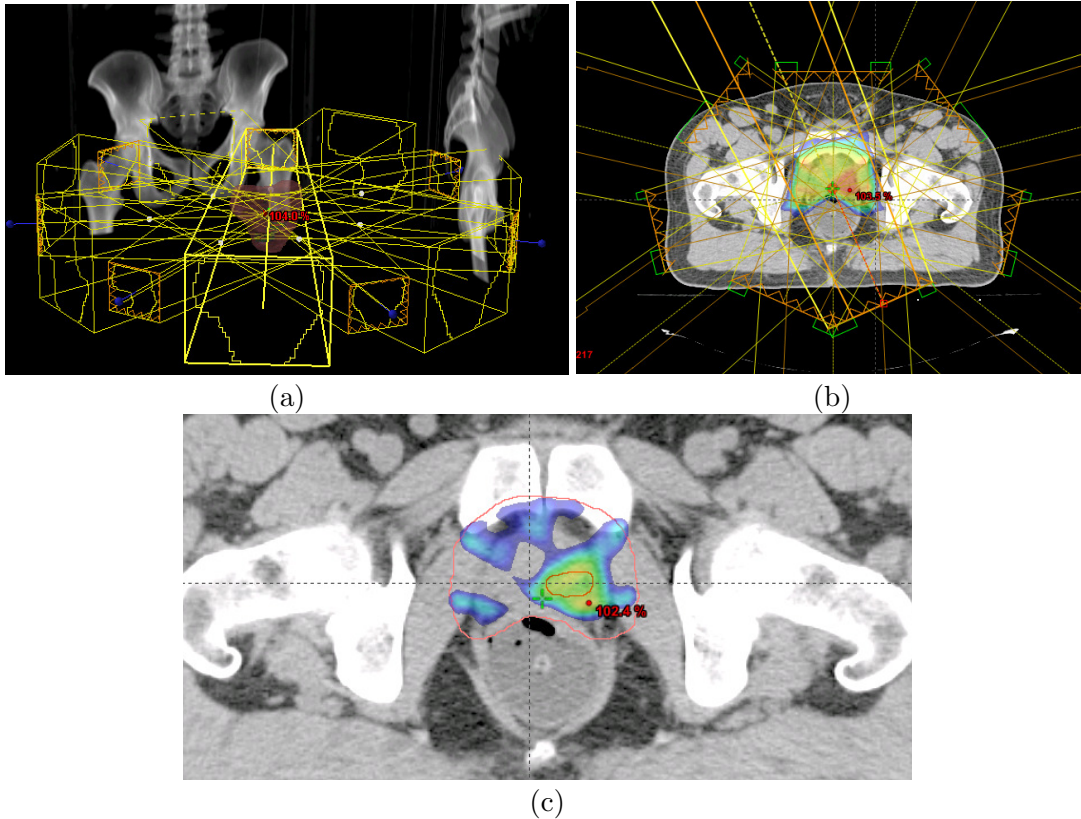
(a) 3D visualization of the orientations and shapes of the 7 dynamically shaped radiation beams used to design the IMRT dose plan. (b) Axial view of a CT slice with the 7 beams and the resulting dose map thresholded at 7920 cGy (minimum dose for the PTV) overlaid. (c) Adjacent CT slice with the dose map thresholded at 8640 cGy (minimum dose for the cPTV) and boundaries for the PTV and cancer overlaid.
